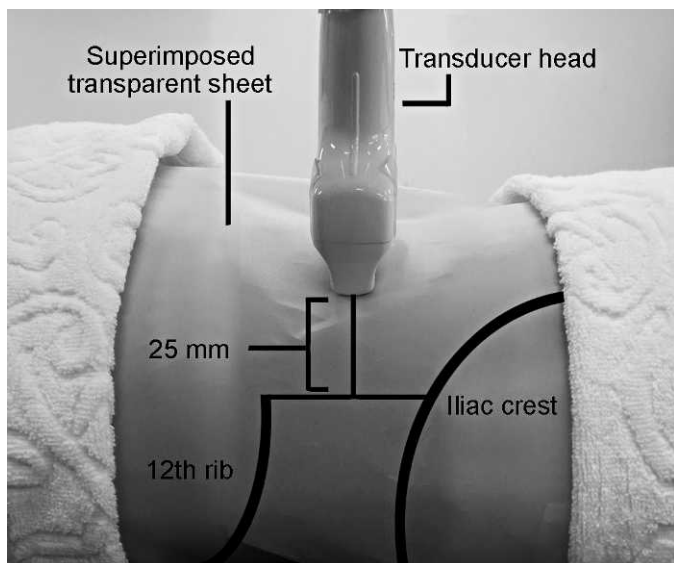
Placement of ultrasound transducer on abdominal muscle.
